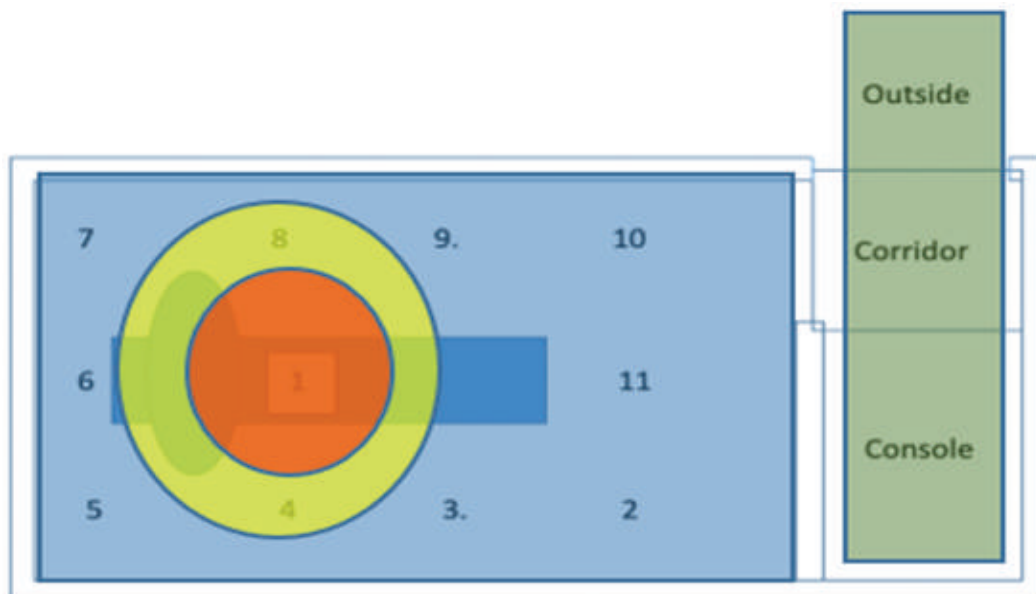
Locations of the specified points in SPECT room
